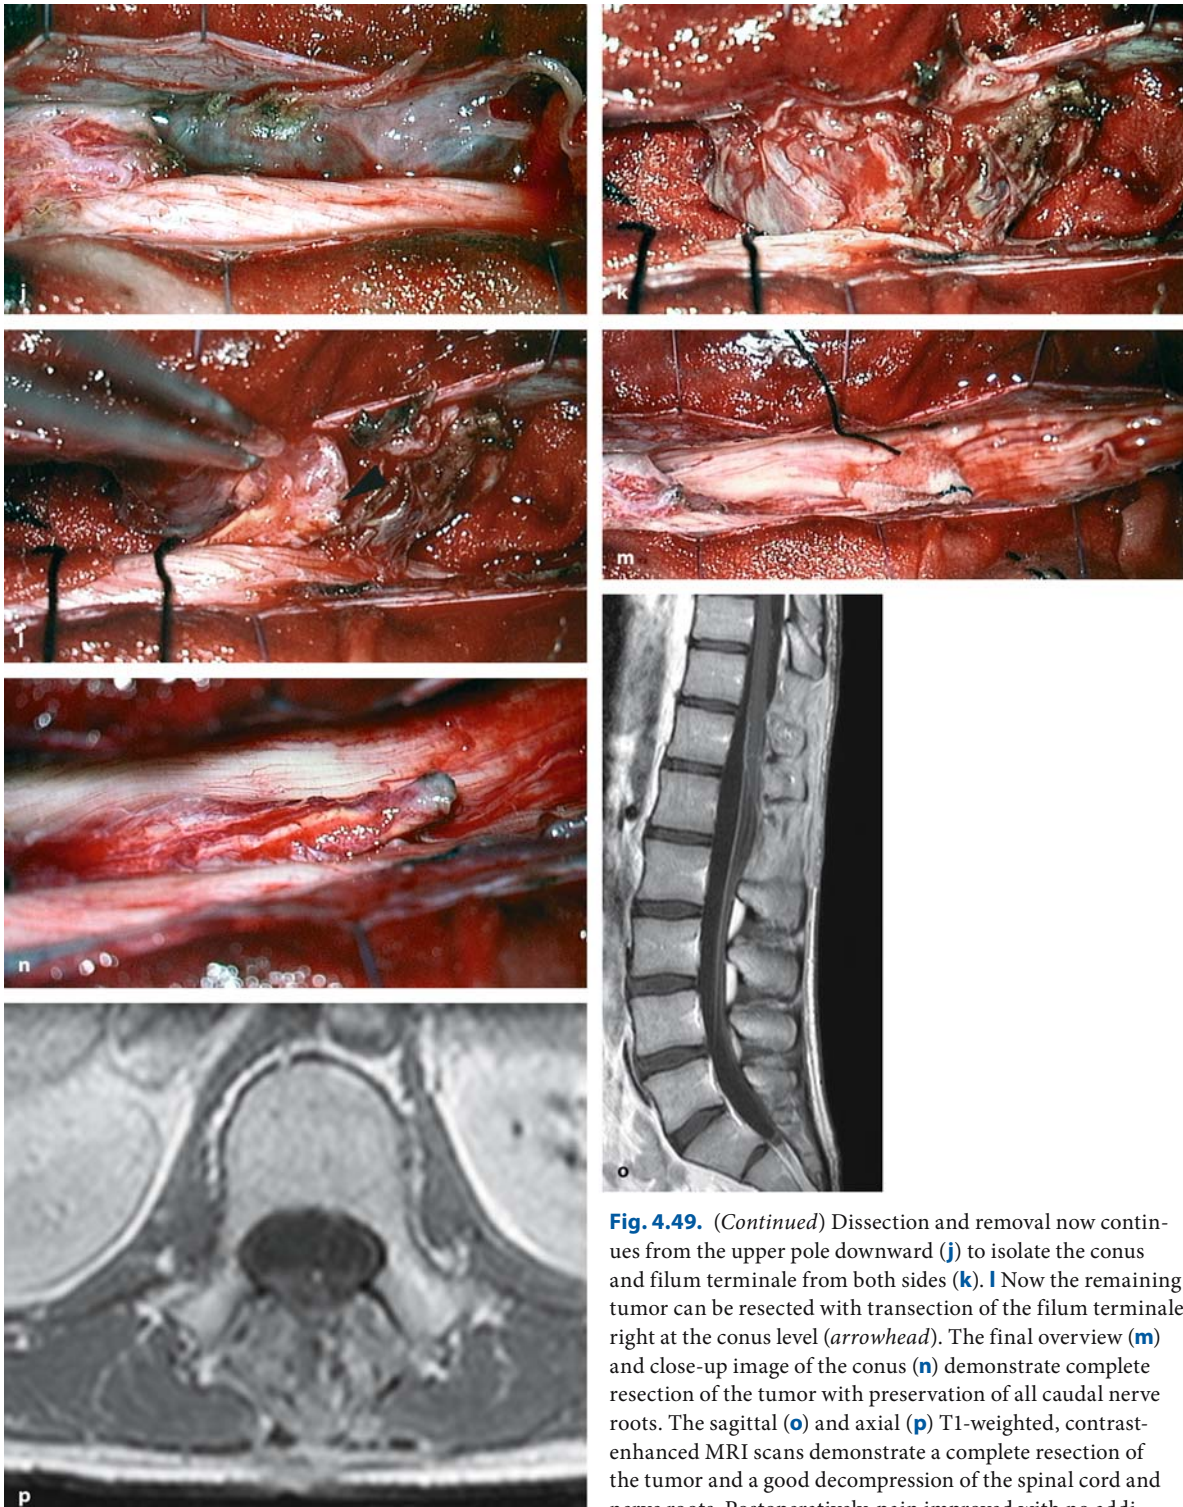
Sagittal (a) and axial (b) T1-weighted, contrast-enhanced MRI scans of an ependymoma at Th12–L2 in a 21-year-old man with a 10-year history of pain without any neurological deficits. The tumor displaces the conus to the left side.
